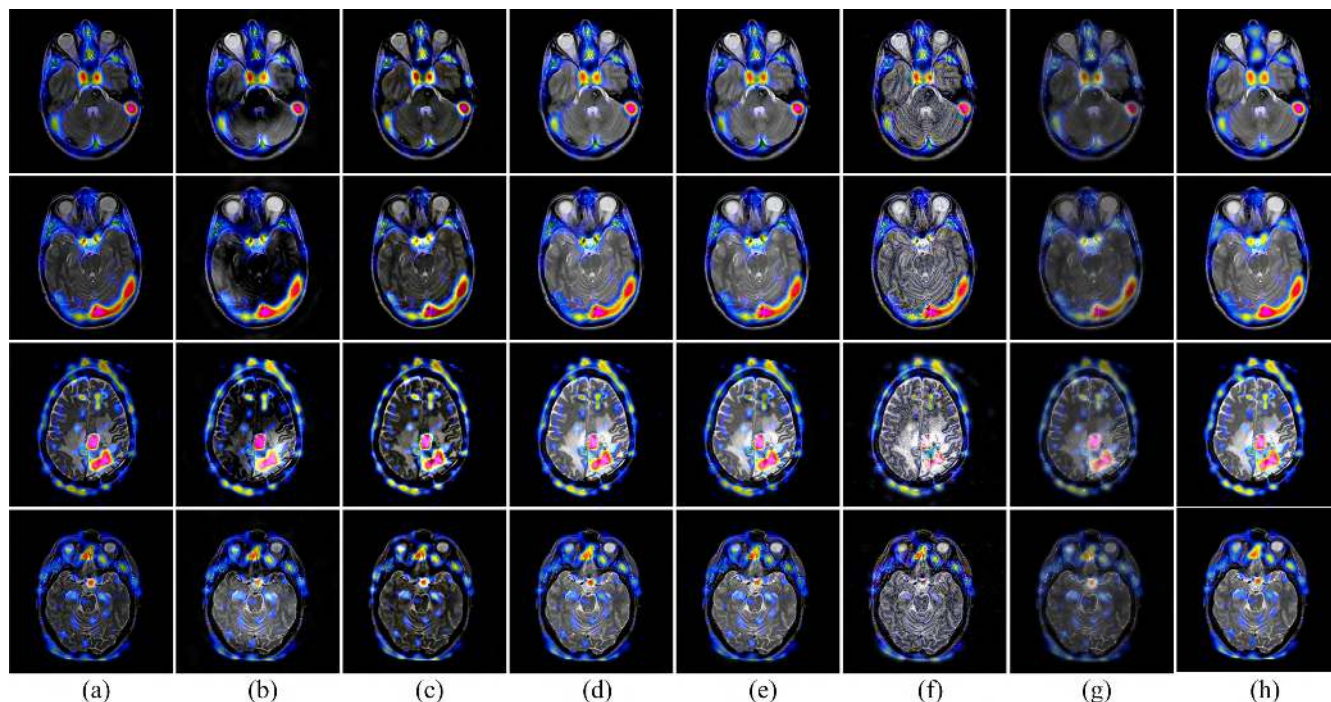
Four experimental results for MR and SPECT image fusion with eight methods. (a) CSR. (b) NSCT-PCNN-SF. (c) ULAP-MF. (d) NF. (e) NSST-PAPCNN. (f) LLF-II. (g)PSF. (h) Proposed.
